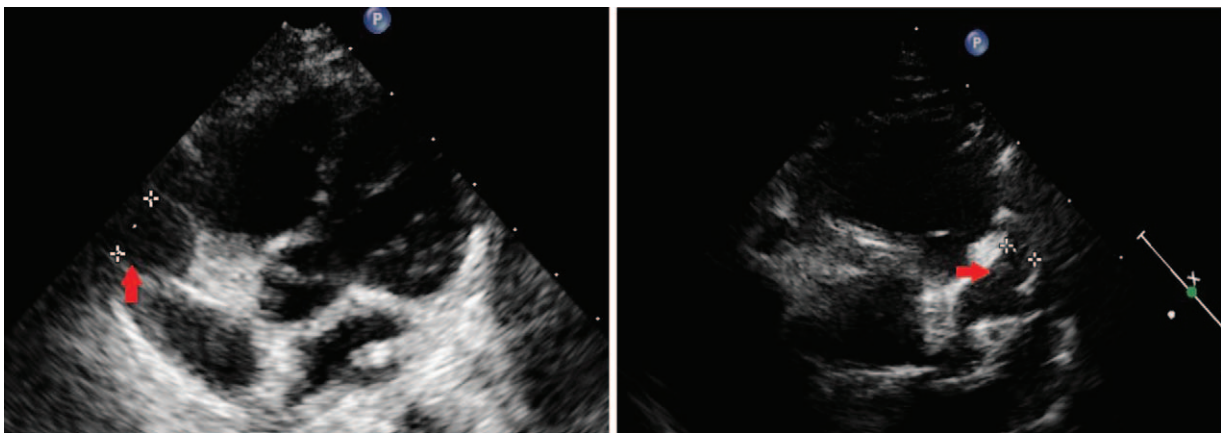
Coronary artery echocardiography. Echocardiographic examination was performed to measure coronary dilation. Shown in this figure is the echocardiograms obtained 1 day before discharge. Right coronary artery dilation is shown in the left-side image (RCA diameter measured at 9 mm as indicated by the red arrow) and the dilation of the left anterior descending artery is shown in right-side image (LADA diameter measured at 5.6 mm, as indicated by the red arrow). LADA=left anterior descending artery, RCA=right coronary artery.
